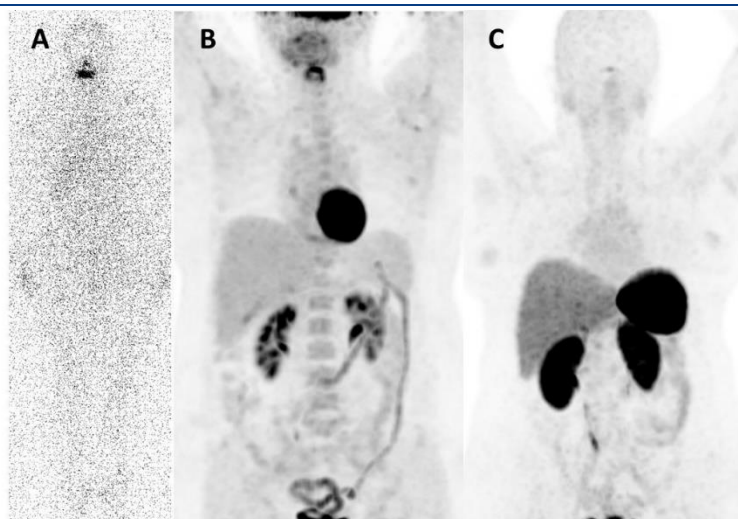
Whole body radio-iodine scan (A), $[^{18}\text{F}]\text{FDG}$ PET/CT scan (B) and whole body $[^{68}\text{Ga}]\text{Ga-DOTATATE}$ scan (C) of the patient
